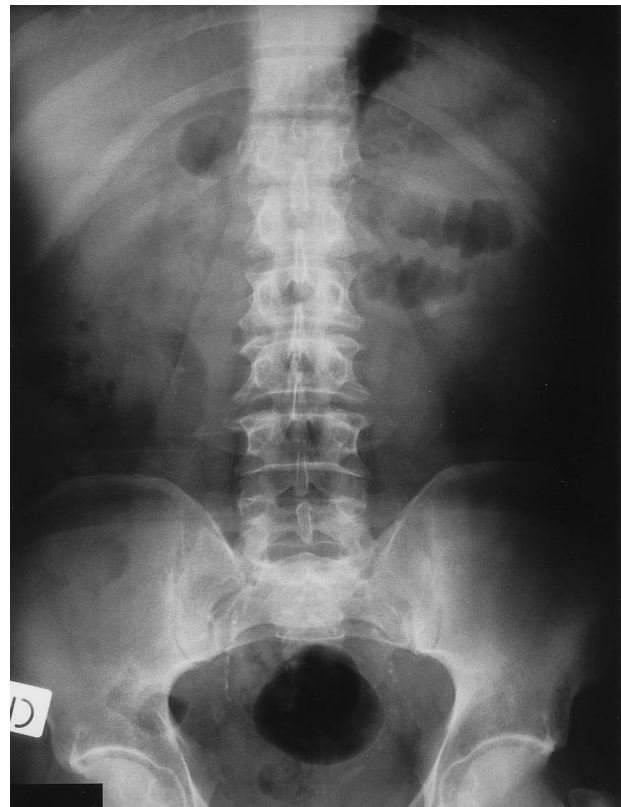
Abdominal plain radiograph 3 weeks after ESWL treatment. The renal stone appears reduced in size, several small fragments are in the lower tract of the left ureter, no bowel distension or air-fluid levels are present.
